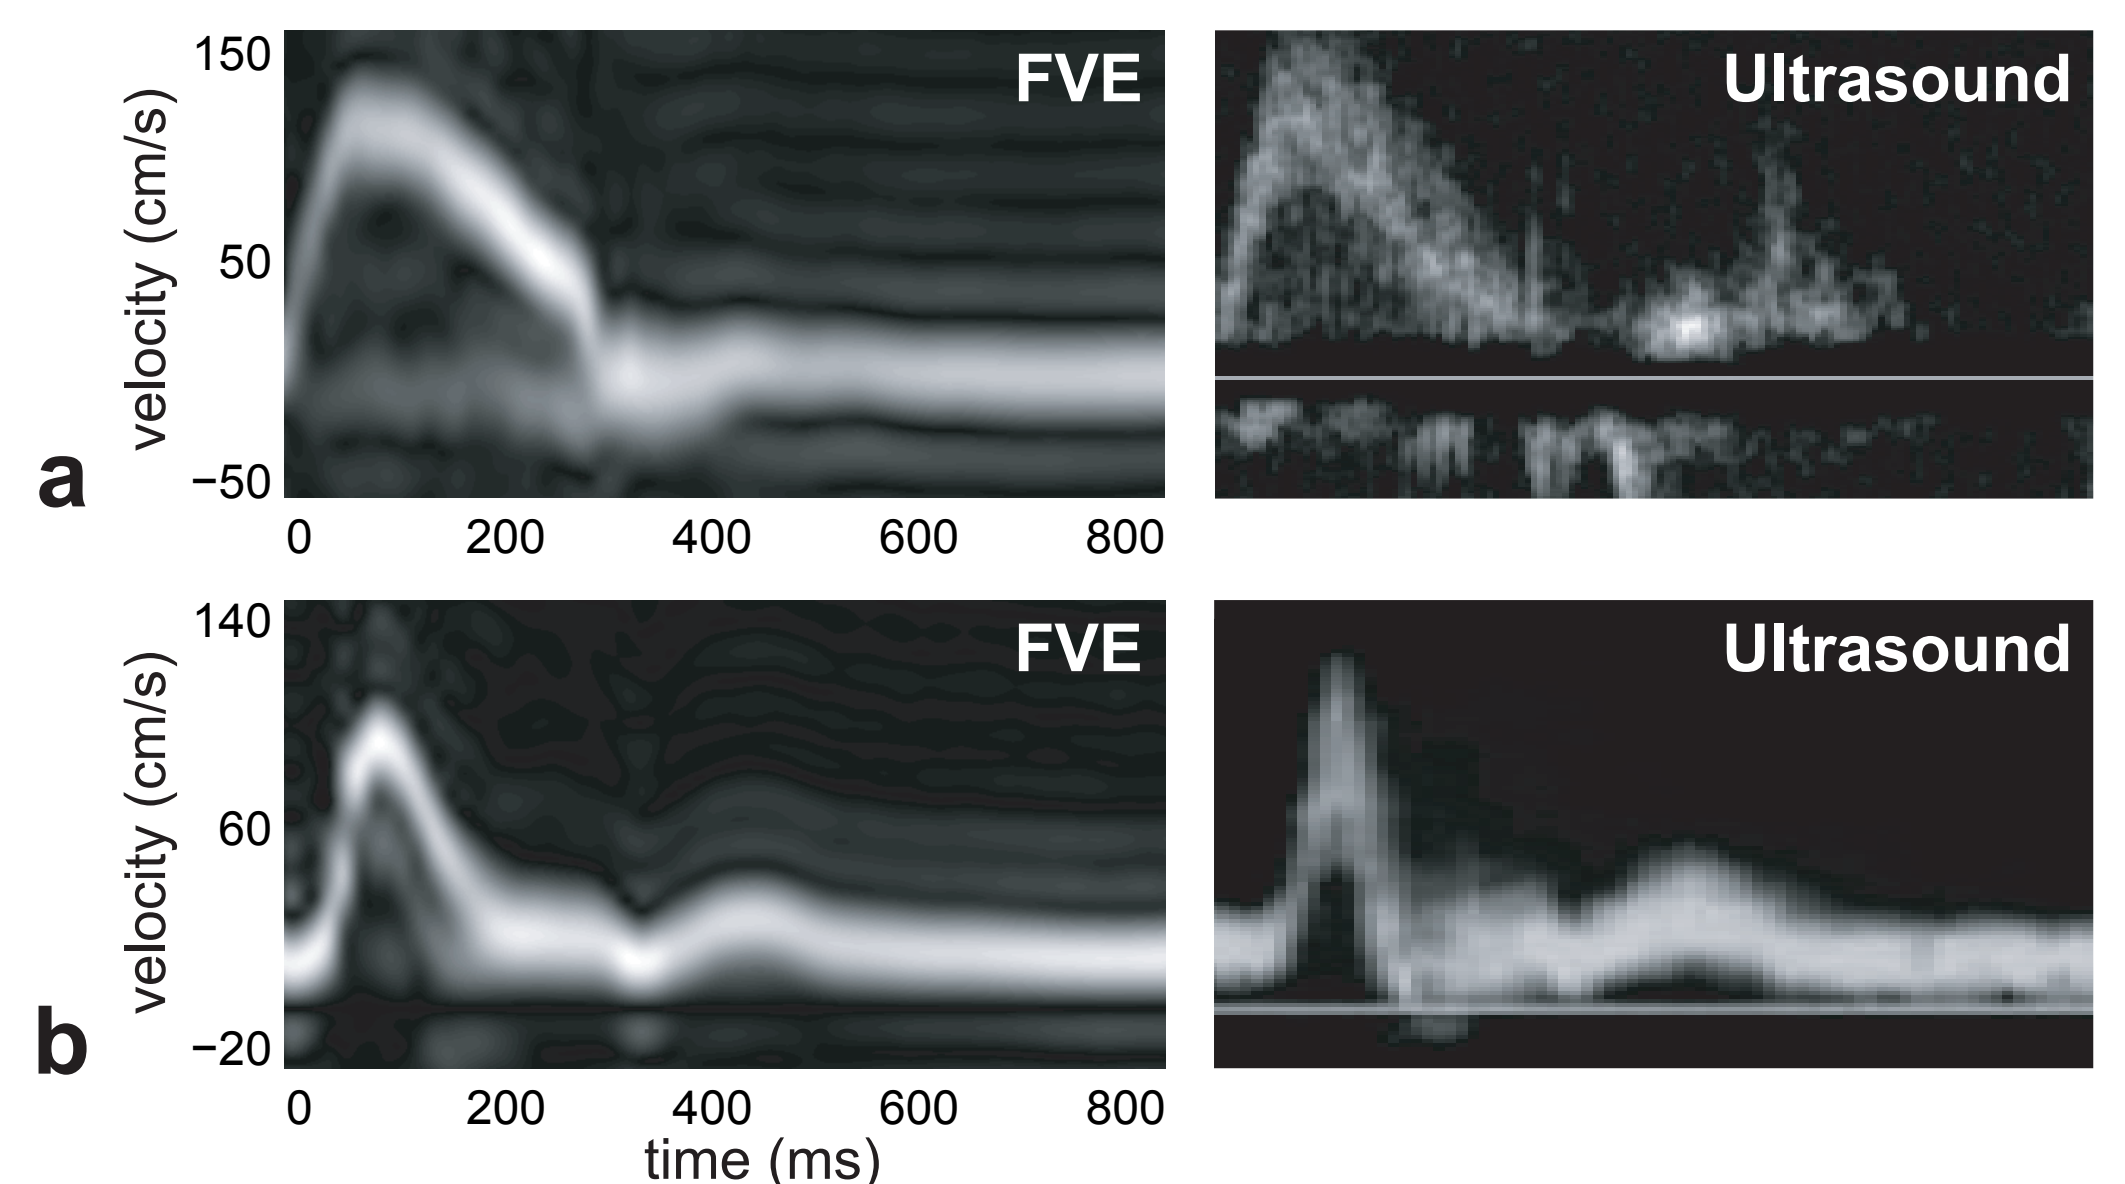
Comparison of the spiral FVE method with Doppler ultrasound, in healthy volunteers: (a) aortic valve and (b) carotid artery. Peak velocity and time-velocity waveforms are in good agreement with the current non-invasive “gold standard”.
